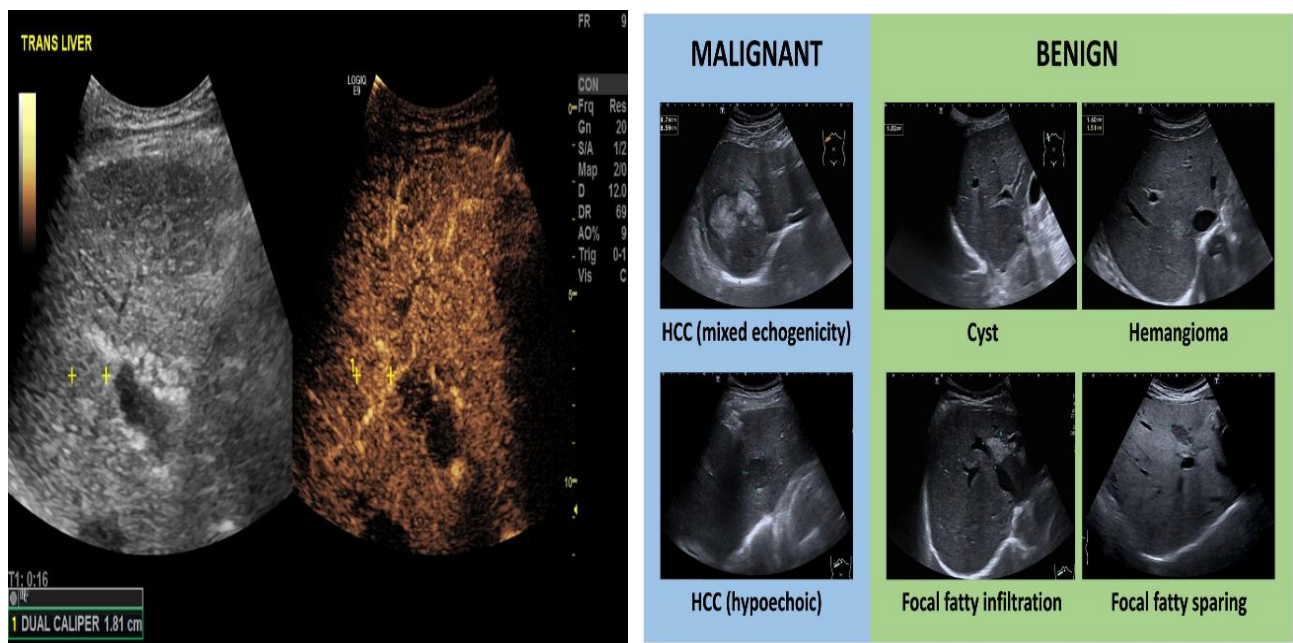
demonstrates the capability of conventional B-mode ultrasound to detect tumors at preclinical stages. Early neoplastic changes were identified as focal lesions with altered echogenicity, irregular or indistinct margins, and heterogeneous internal structure. These structural abnormalities were observed before the appearance of clinical symptoms, confirming the effectiveness of ultrasound as an early diagnostic modality.
